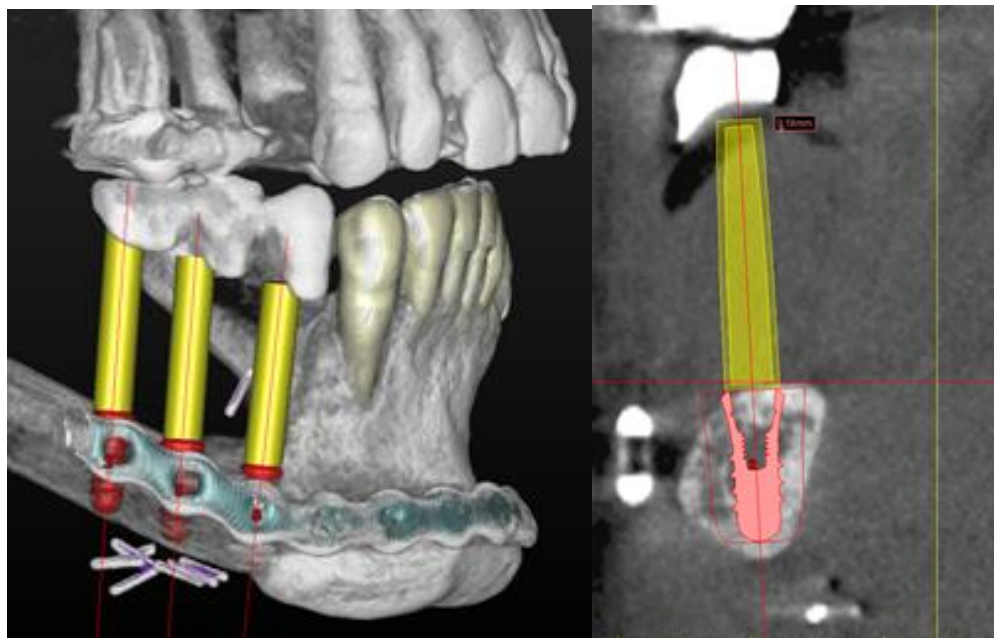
CBCT reformatted for SIMPLANT planning software with a radiographic stent in the form of a prosthesis with radiopaque teeth (barium sulfate) showing the relationship between required tooth position and planned implant fixtures into a single barrel fibula flap.
